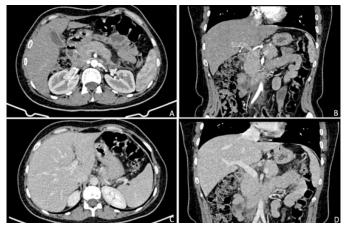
Pre-operative CT scan showing an acute pancreatis. No angioma, tumor or vascular malformation were apparent (A) Arterial phase axial maximum intensity projection; (B) Arterial phase coronal maximum intensity projection; (C) Portal venous phase axial maximum intensity projection; (D) Portal venous phase coronal maximum intensity projection
